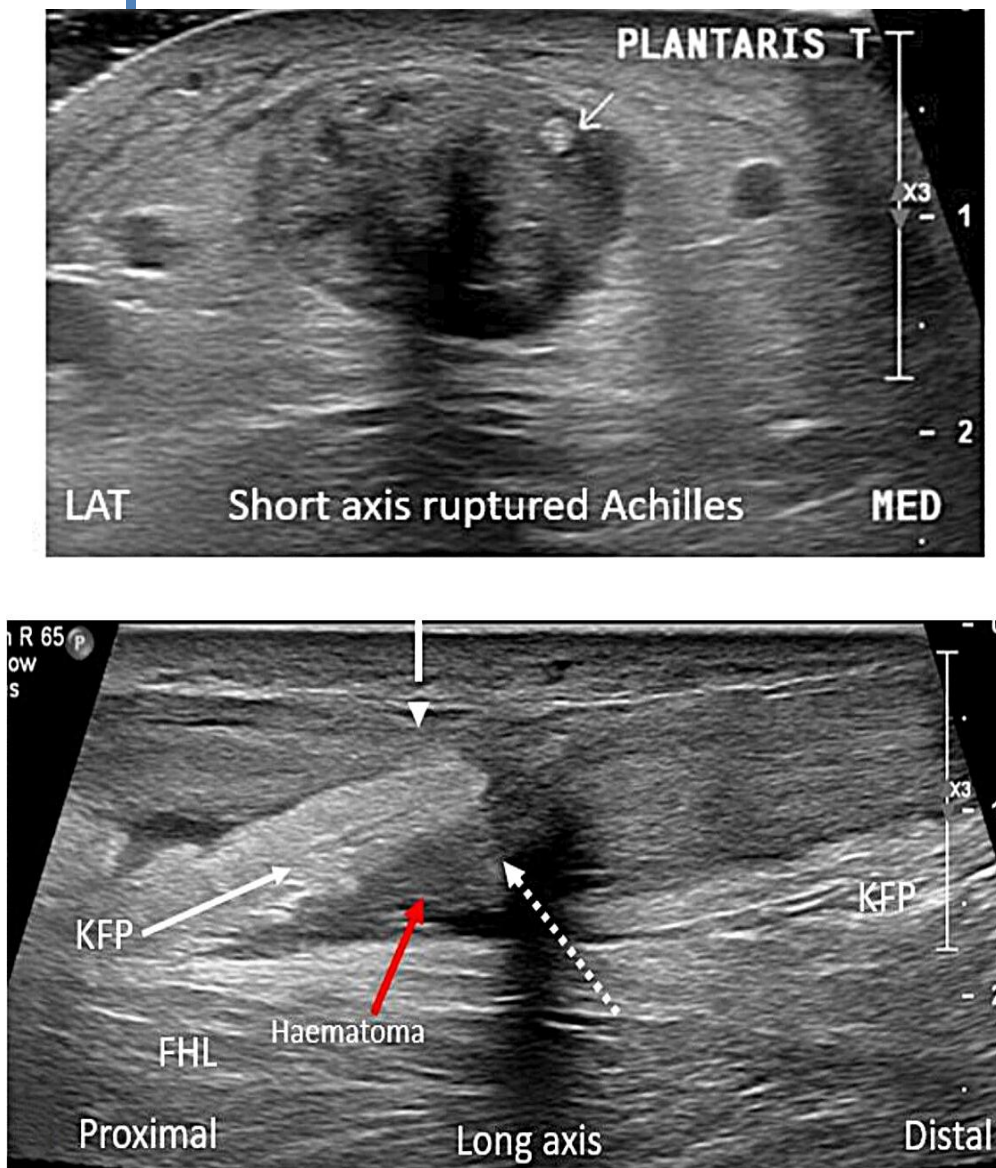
Short-axis imaging of ruptured Achilles tendons and associated findings, Intact plantaris tendon. ((Long-axis sonographic imaging of acutely ruptured Achilles tendon (mid tendon)., Kager's fat pad (KFP) can be seen herniating superficially and inferiorly through the gap between the proximal (dashed arrow) and distal (dotted arrow) tendon ends. FHL, Flexor hallucis longus muscle; KFP, Kager's fat pad; LAT, lateral aspect of a short axis image; MED, medial aspect of a short axis image ⁽³⁴⁾).
